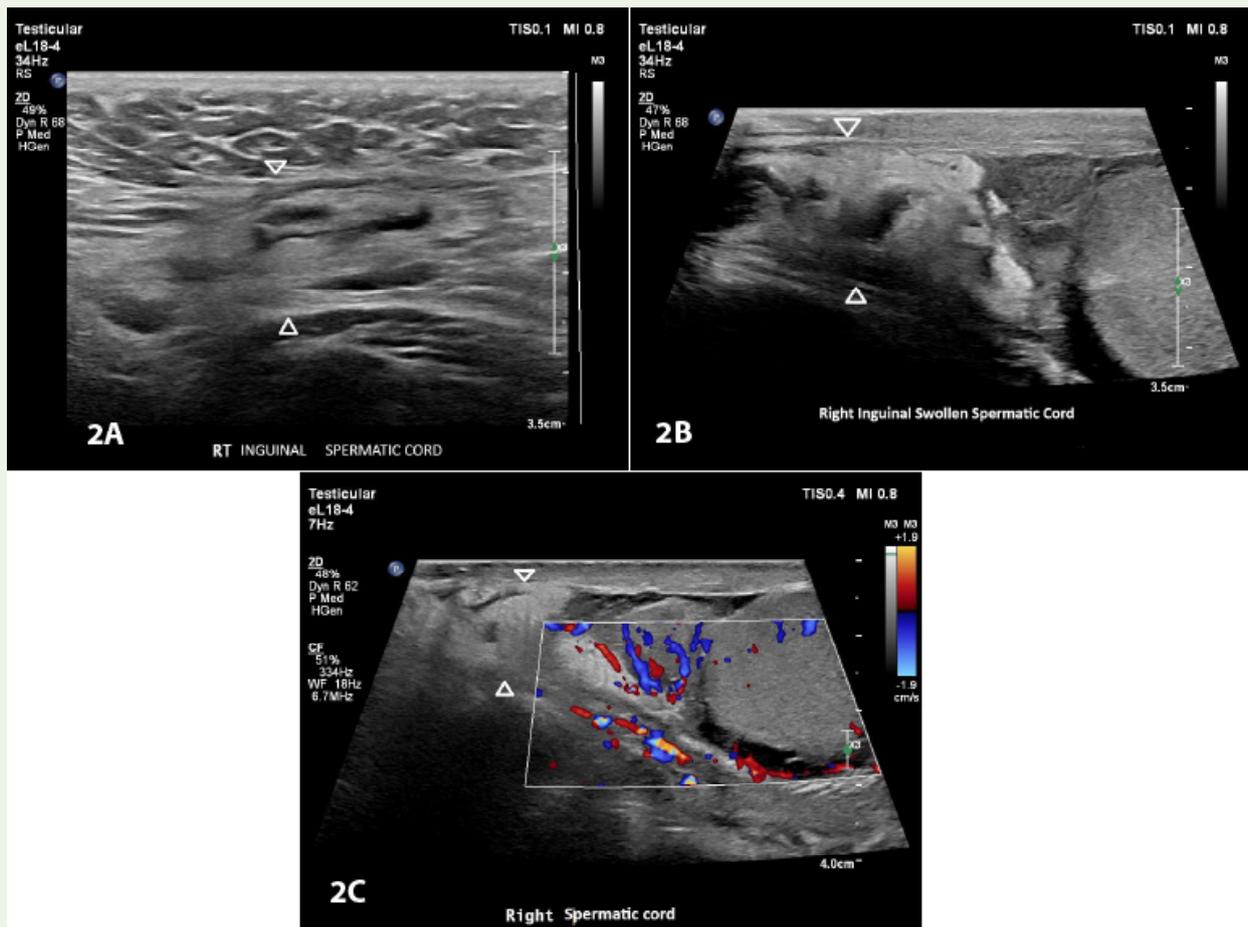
Sonographic images of the right spermatic cord shown within arrowheads. (A) Gray scale image of the right spermatic cord in the inguinal canal. Spermatic cord is thickened within arrowheads and hyperperfused with echogenic fat. (B) Gray scale image of the right spermatic cord entering the scrotum. (C) Color Doppler image of a small section of the spermatic cord and right testicle.
